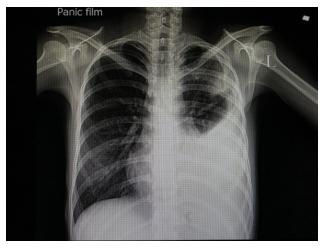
Anteroposterior (AP) chest radiograph of a patient with pneumonia and a left-sided pleural effusion. © Tomatheart/Shutterstock.
